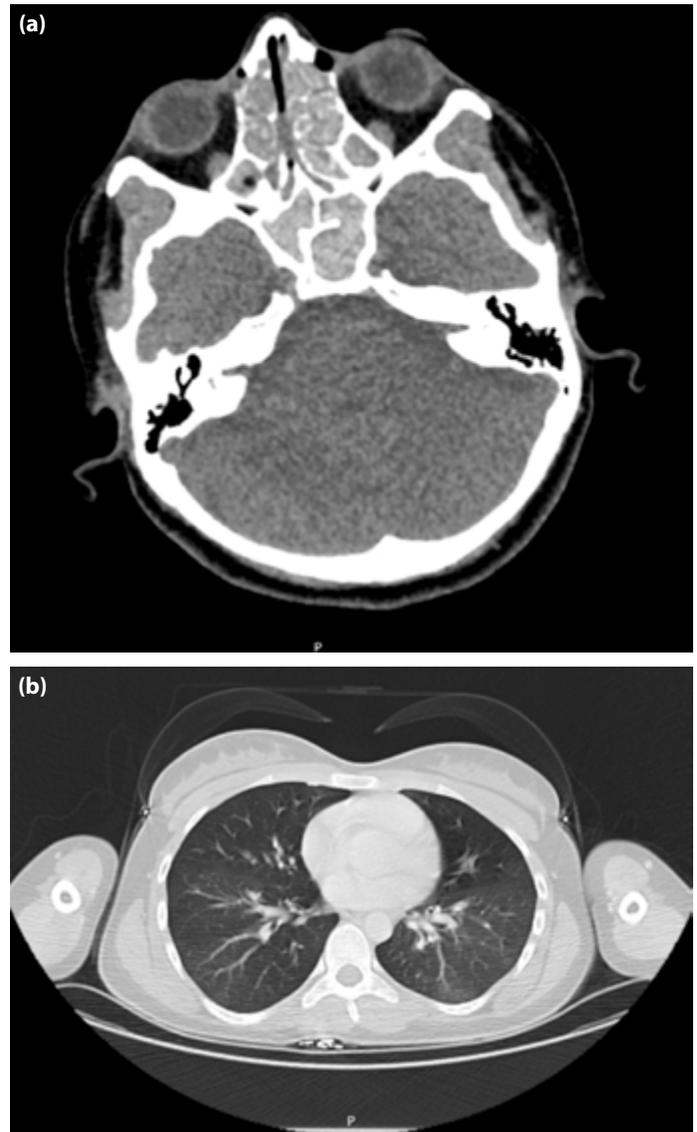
(a) Paranasal sinus CT image of the patient. (b) Thoracic CT image of the patient. Şeklinde düzeltilmeli.
